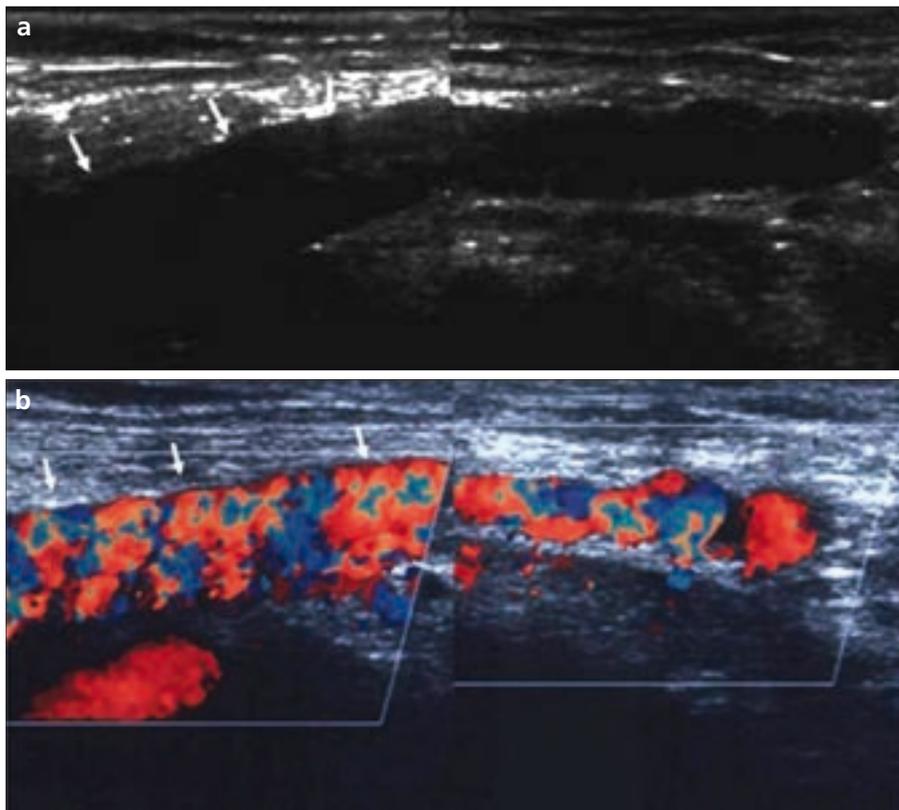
a, b. Sagittal gray-scale (a) and color Doppler imaging (b) reveal the lesion extending from the right inguinal canal to the abdominal cavity (arrows).
